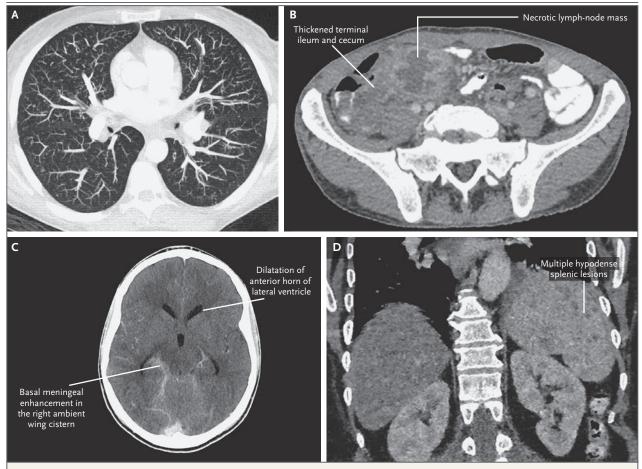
Computed Tomographic Scans Showing Certain Features of HIV-Associated Tuberculosis.
